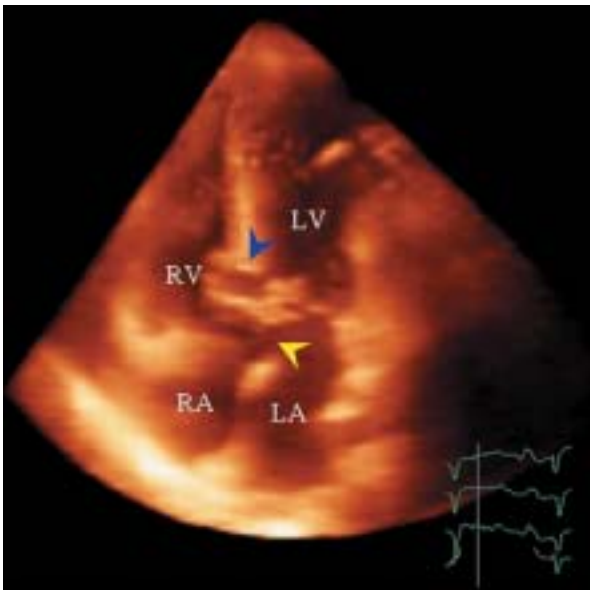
Three-dimensional echocardiogram
